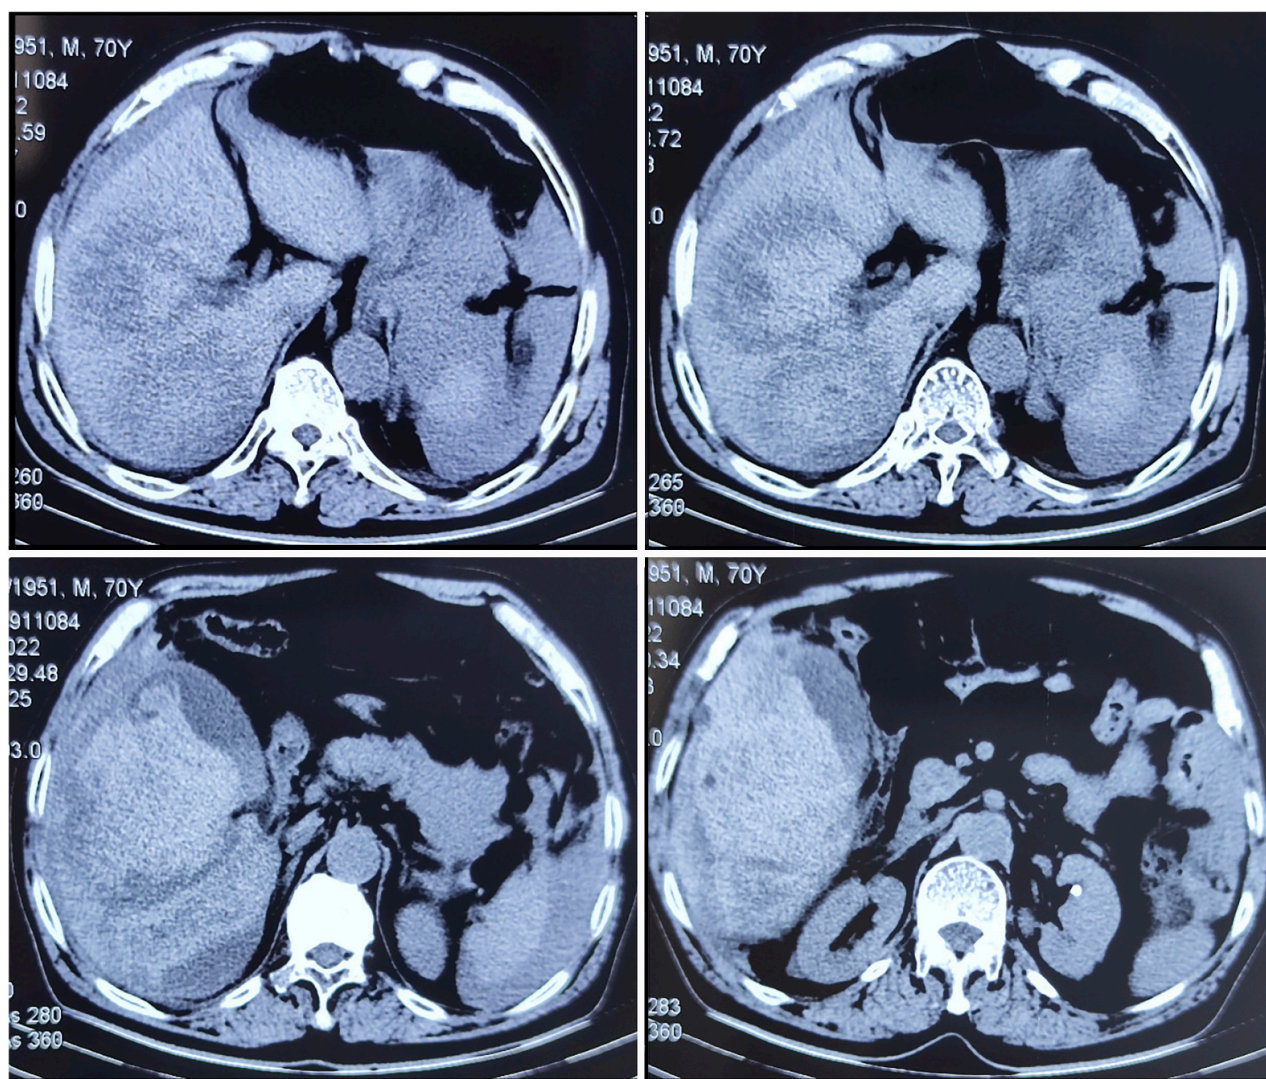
Abdominal computed tomography revealing a mixed density shadow in the right lobe of the liver combined with abdominopelvic effusion and an enlarged gallbladder adjoining the mass.
